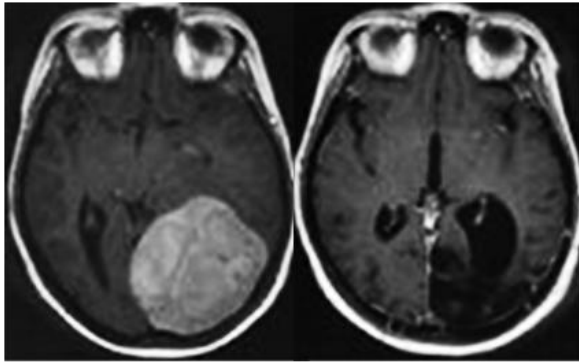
MRI image of occipital meningioma before and after surgery
